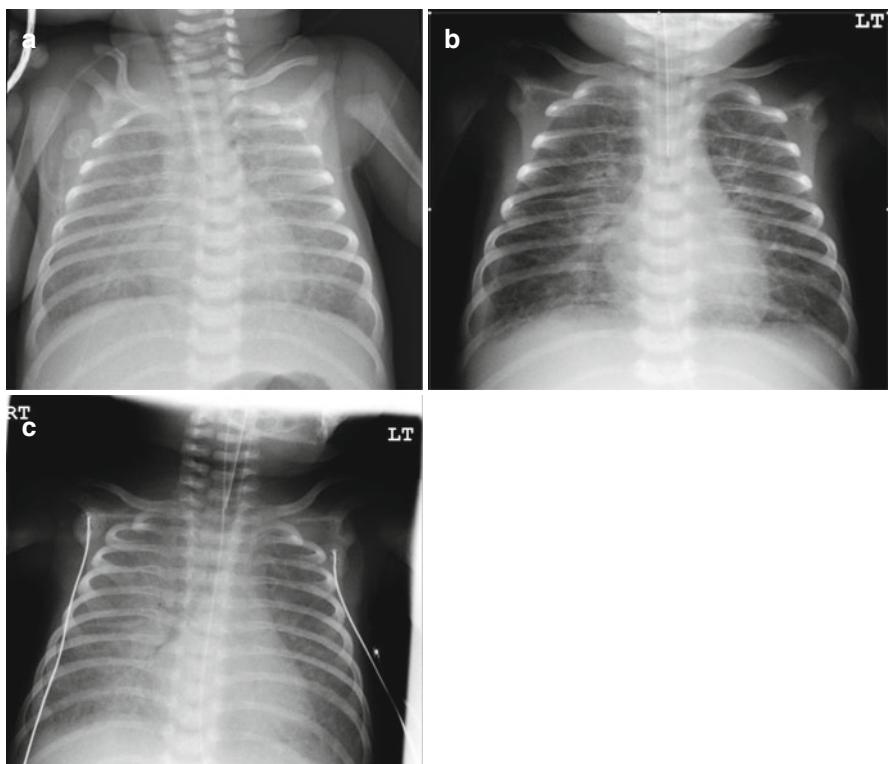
(a, b, c) Serial chest radiographs showing a relatively normal cardiothoracic ratio and pulmonary venous congestion
